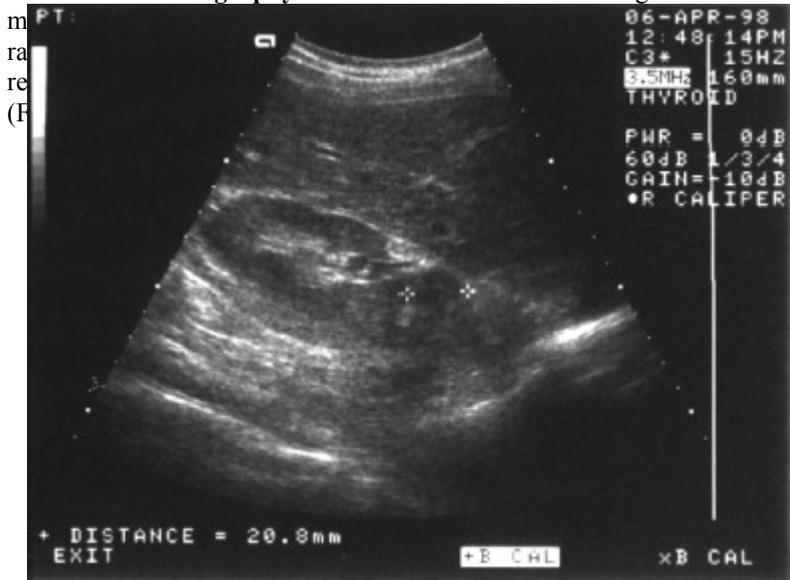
Renal ultrasonography, signs of chronic pyelonephritis.
